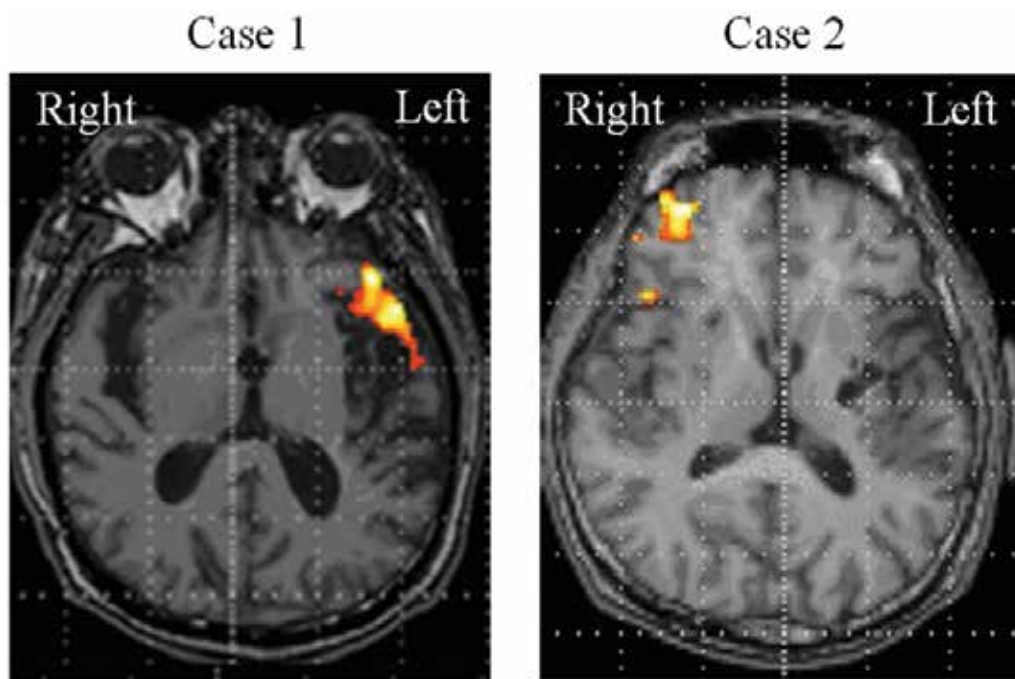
Axial images of functional MRI with repetition tasks prior to rTMS. Activation on functional MRI was found in the peri-lesional area of the left hemisphere in Case 1 and in the right frontal cortex in Case 2.
